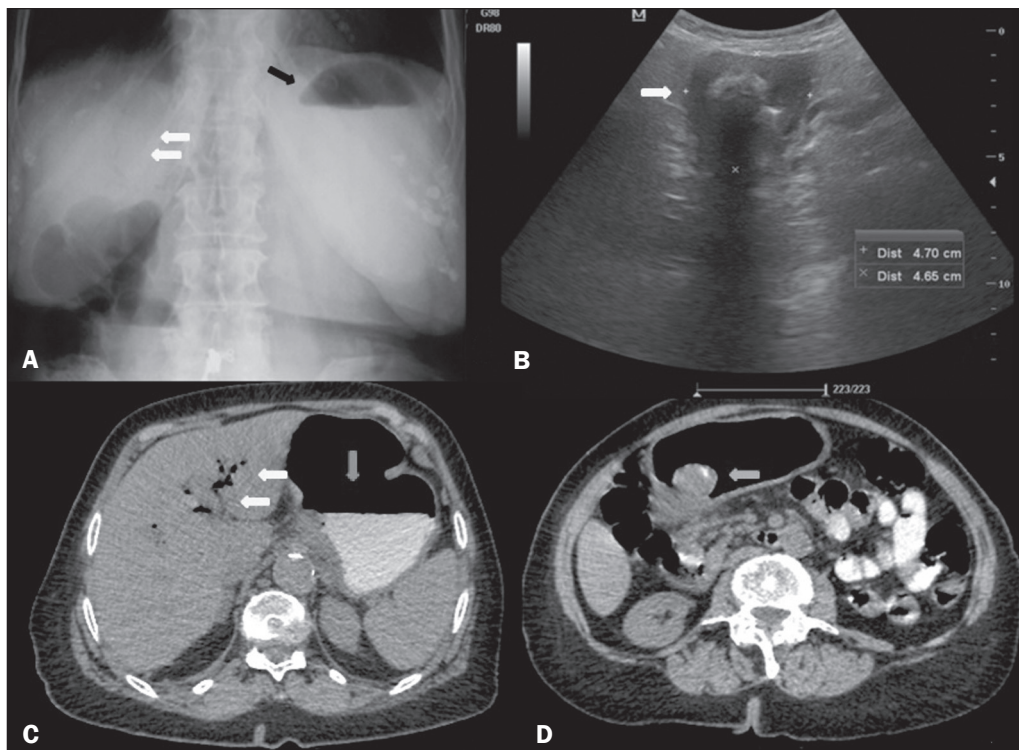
A: X-ray of the abdomen, with the patient standing, showing an air-fluid level in the stomach (black arrow) and intrahepatic pneumobilia (white arrows). B: Abdominal ultrasound showing the pyloric-duodenal region with a calculus impacted in its interior (arrow). C: Oral contrast-enhanced computed tomography of the abdomen, showing an air-fluid level in the stomach (vertical arrow) and gaseous content in intrahepatic biliary tracts/pneumobilia (horizontal arrows). D: Oral contrast-enhanced computed tomography of the abdomen, showing a mixed-density calculus in the pyloric region (arrow), causing upstream obstruction and dilation (i.e., of the stomach).
